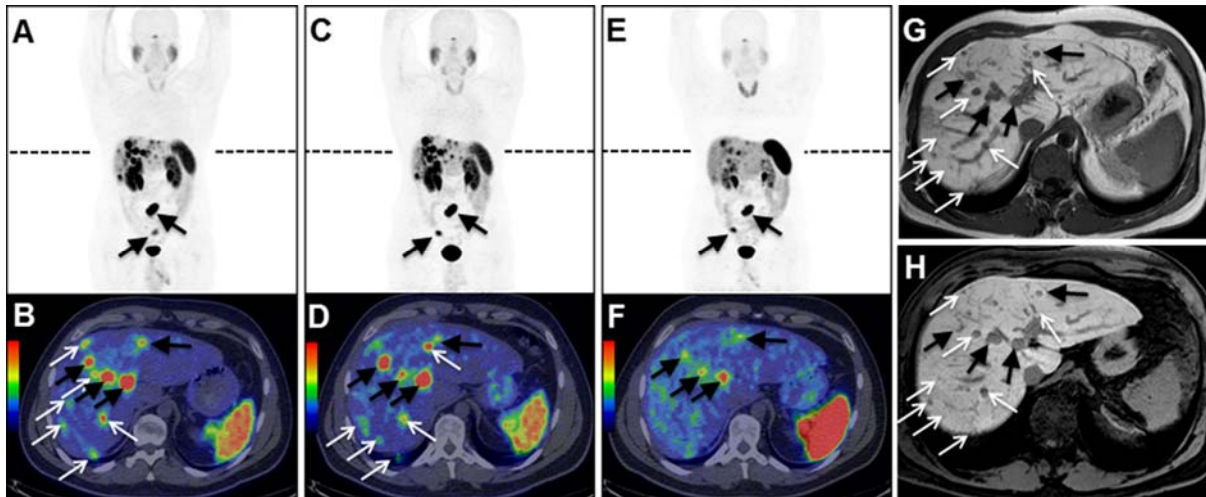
^{68}Ga -OPS202 PET/CT (50 μg) (A, B), ^{68}Ga -OPS202 PET/CT (15 μg) (C, D), ^{68}Ga -DOTATOC PET/CT (15 μg) (E, F) acquired 1 h p.i and MRI scans (G, H) in patient 10 with an ileal NET. Dotted lines show the level of transaxial slices. ^{68}Ga -OPS202 scans are performed 25 and 4 days after ^{68}Ga -DOTATOC PET/CT. Mean liver SUVmax was 4.6 and 4.7 for 15 and 50 μg ^{68}Ga -OPS202 and 5.6 for ^{68}Ga -DOTATOC. While ^{68}Ga -DOTATOC and both ^{68}Ga -OPS202 PET/CT showed the ileal primary, a mesenteric malignant mass and multiple liver metastases (black arrows), ^{68}Ga -OPS202 PET/CT scans detected significantly more liver metastases (white arrows). Head-to-head comparison with MRI performed 7 months after ^{68}Ga -OPS202 scans confirmed the suspicious findings as true positive only on ^{68}Ga -OPS202 PET/CT scans (white arrows).
